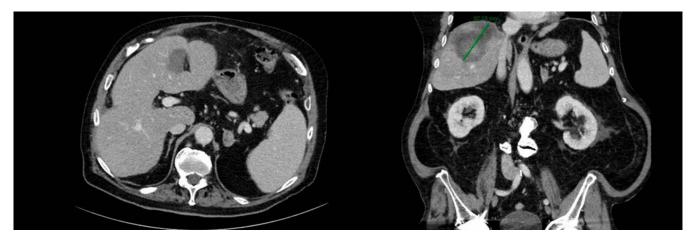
A computed tomography scan 5 days after the ablation showing a 6 cm hematoma.
